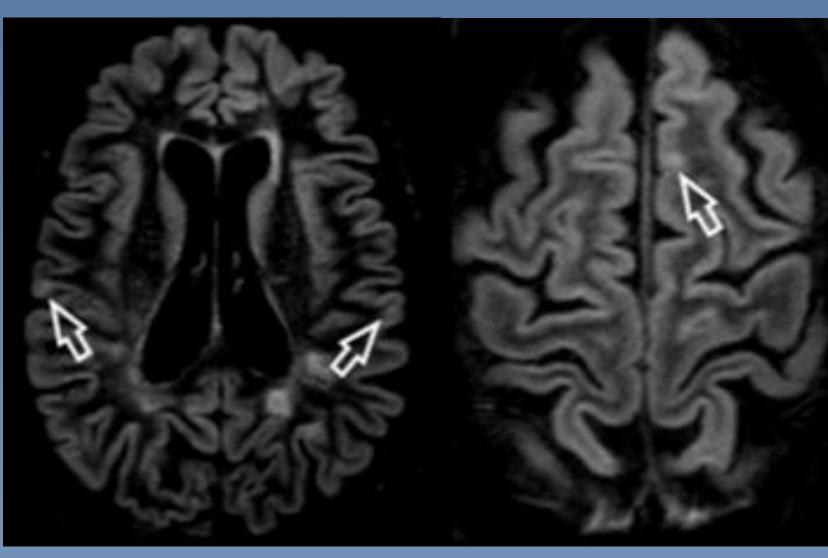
Axial DIR MR images of the brain in a patient with primary progressive MS demonstrating focal lesions in the cortical grey matter (arrows).
